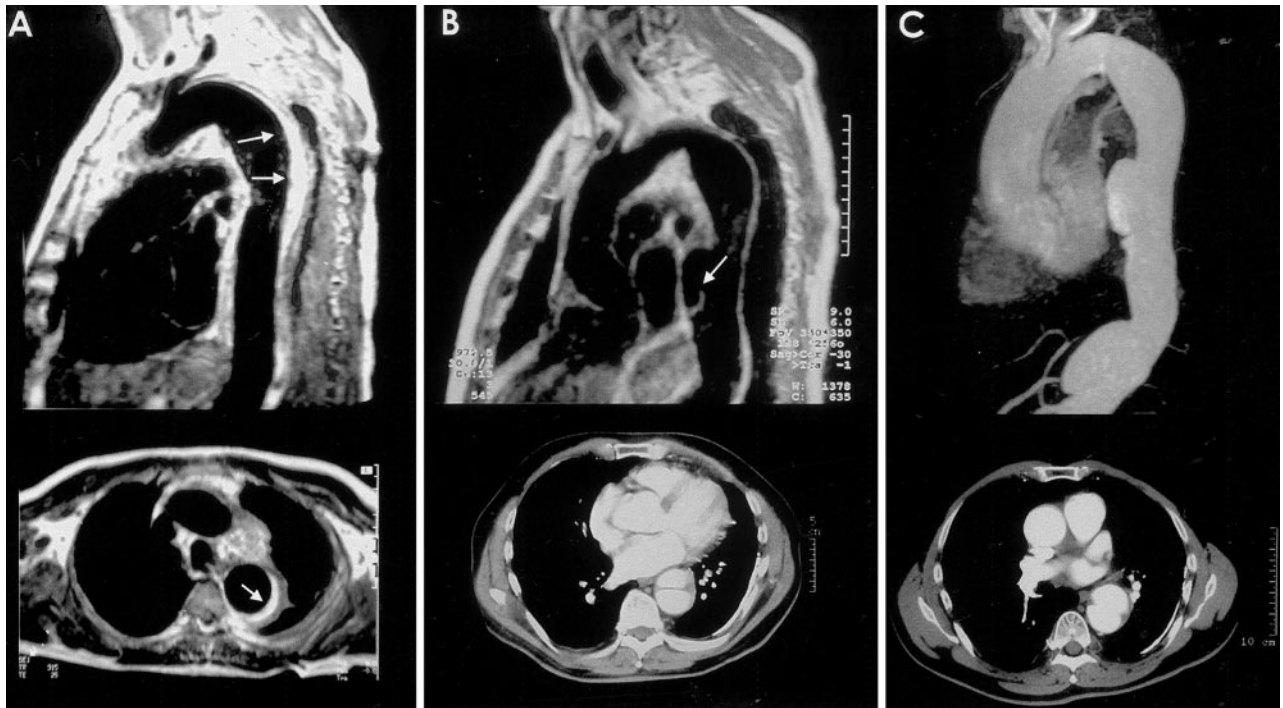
IMH evolving to pseudoaneurysm over a 4-year period. A, In the acute phase, MRI shows a high signal intensity suggestive of IMH. Top, Sagittal view demonstrates IMH in the upper and middle third of the descending thoracic aorta; bottom, IMH adopts a crescentic form in the axial view. B, At 6 months of follow-up, MRI in sagittal view (top) reveals a localized dissection; bottom, CT scan at this level displays typical dissection. C, At 4 years of follow-up, in sagittal view by gradient echo sequence (top), 2 pseudoaneurysm formations are observed, 1 in the site of localized dissection and another in abdominal aorta; bottom, CT scan shows that the intima has almost completely disappeared.
